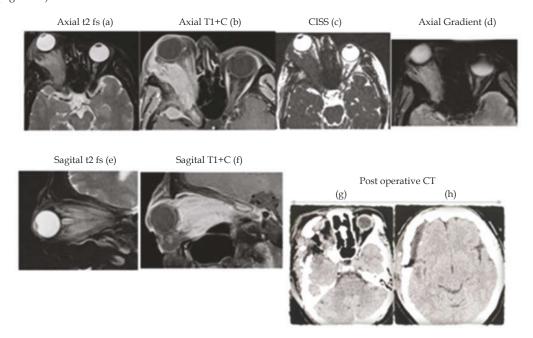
(a-to-h): MRI Brain with Orbit (a-to-f), (b) showing dural tail enhancement within the cranium, (d) Gradient scan showing hyperostosis of the right sphenoid wing. (c) CISS (constructive interference steady state) to see tumor vascularity. (e) Shows mass is arising from sphenoidwing, not from the optic nerve. CT Orbit (g, h): post operatively.
